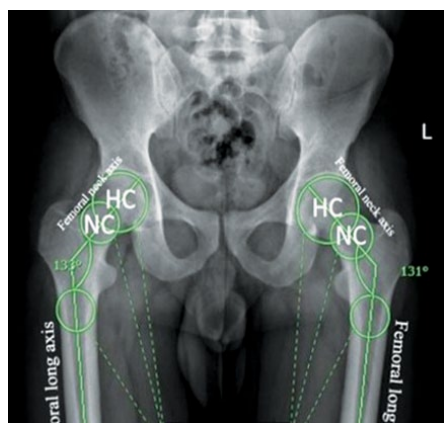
Neck-shaft angle measurements on an upright pelvis plain X-ray
